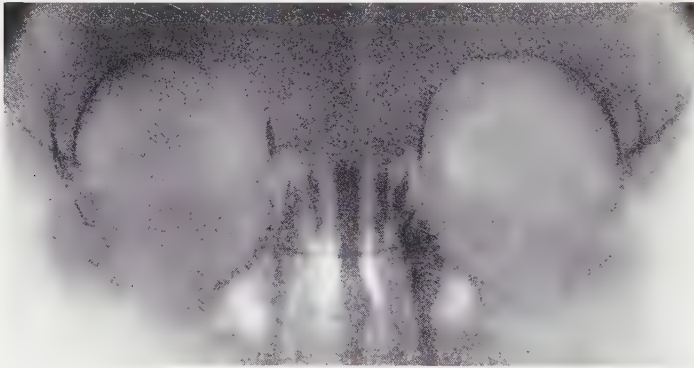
Half-axial roentgenogram of the skull of a ten-month-old child with hypertelorism. The interorbital distance of this case is 2.50 cm.
